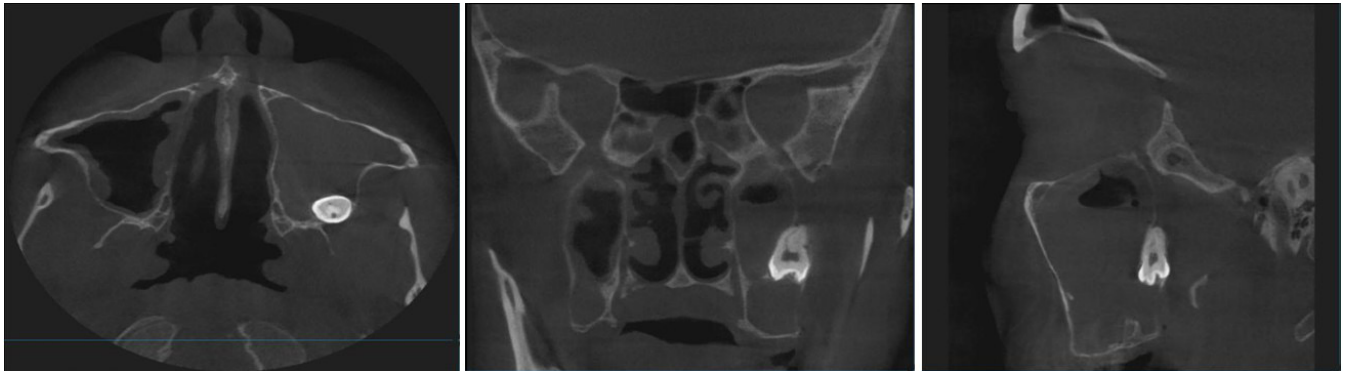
CT of a female patient with the 28thretinal and dystopian tooth in the lumen of the maxillary sinus, adjacent to the posterior lateral wall of the maxillary sinus
